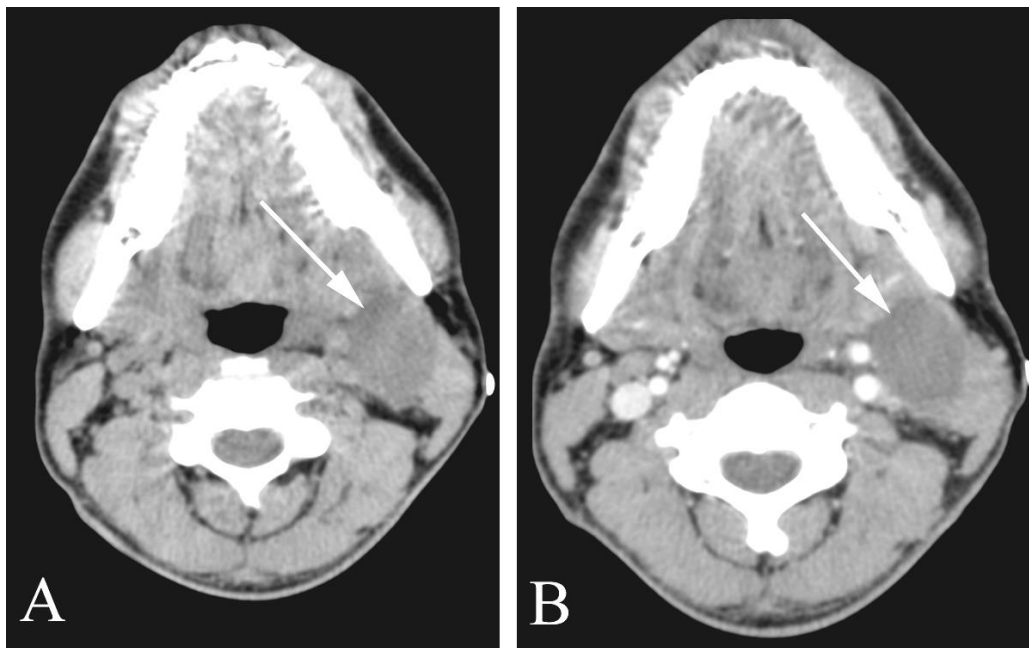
Branchial cleft cyst in a 32 year old man with a palpable neck mass. A. Axial noncontrast enhanced neck CT shows a mass superficial to the carotid artery and posterior to the mandible (arrow). B. Axial contrast-enhanced neck CT shows a lack of contrast enhancement of the lesion, which proved to be a branchial cleft upon removal.
